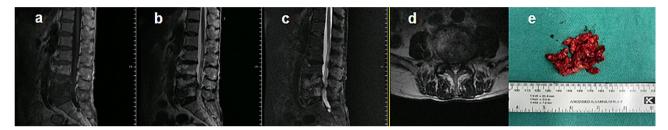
The patient is a 49-year-old male with L4-5 brucellar spondylitis. (a-d) show MRI images revealing bone destruction at the L4-5 level, decreased intervertebral disc space, and notable disc deterioration. (e) shows the fragmented intervertebral disc and granulation tissue that were surgically debrided
